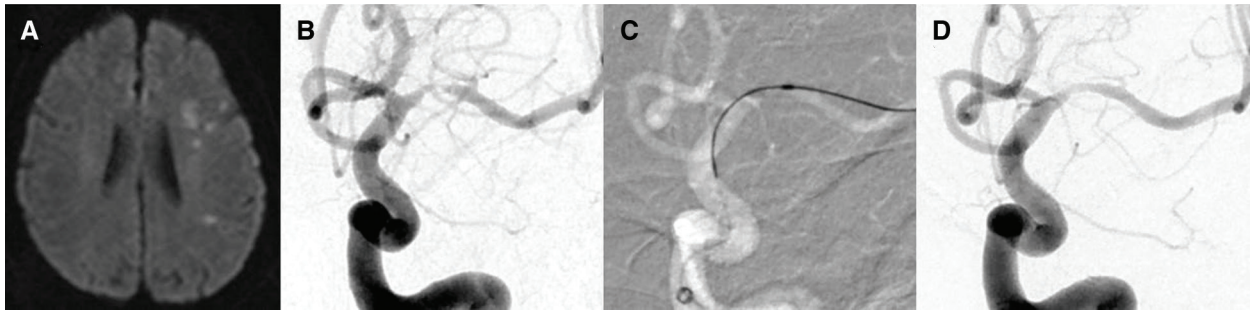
(A) Diffusion-weighted MRI showed sporadic acute cerebral ischemic lesions at the left watershed area. (B) DSA showed severe stenosis in the proximal M1 segment of the left middle cerebral artery. (C) Angioplasty was performed using a 1.5 × 9-mm Gateway
